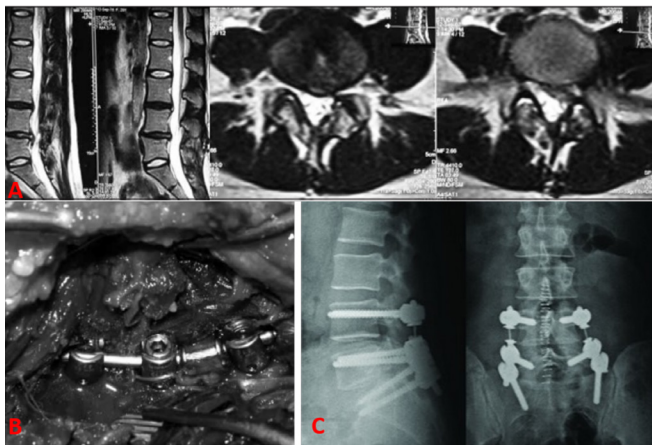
Thirty-year-old male patient with severe left leg pain and recurrent disc hernia. Sagittal and axial section MRIs (A) and intraoperative view (B) are seen. An agile rod was used with dynamic screws. Antero-posterior and lateral radiographic views after the operation (C)
